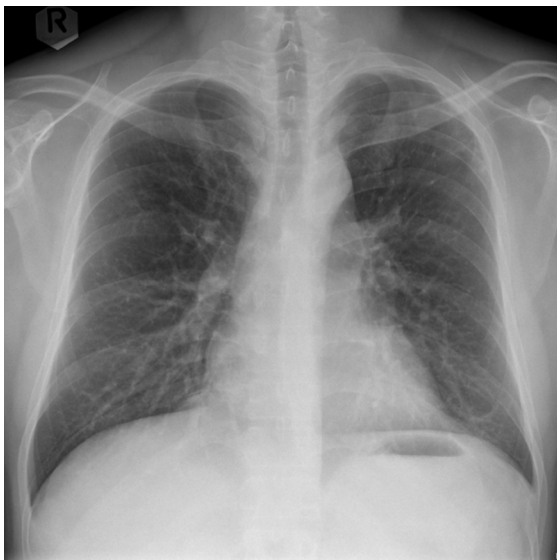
Thorax X-ray with increased echogenicity showing past tuberculosis infection.
